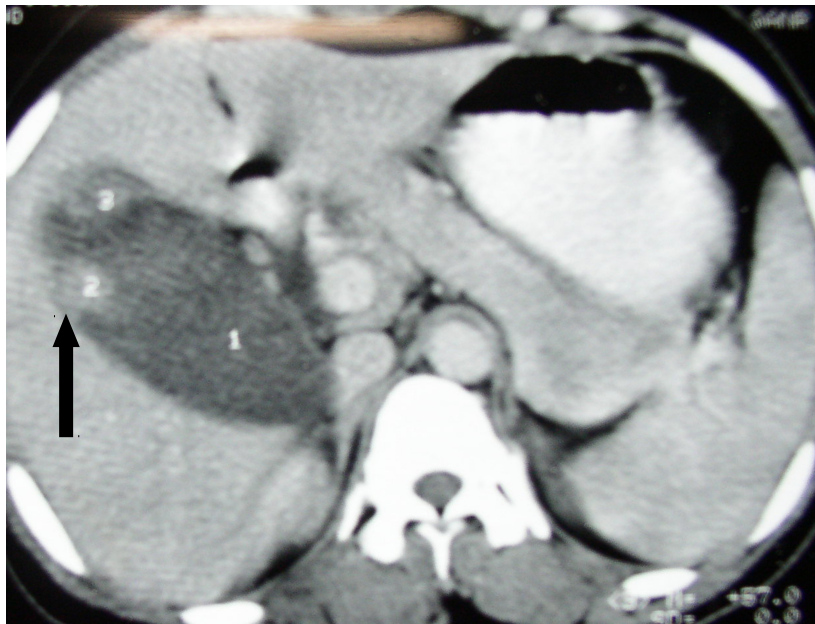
2 CT Scan - Gall-bladder carcinoma
